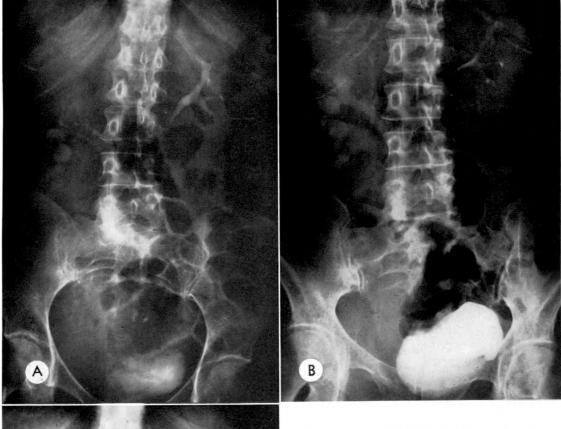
Case iv. (A) Early intravenous pyelogram with 50 cc. of renovist made during episode of right flank pain shows early extravasation of the contrast material in the periureteral tissue around the upper ureter draining the upper collecting system. As noted, the patient has a double collecting system. Notice negative outline of ureter in contrast material. A large right sided pelvic mass indents the right side of the bladder. (B) One-half hour pyelogram shows further extension of extravasation. The ureter to the upper calyces is now outlined with contrast material and separated by the non-opaque wall of the ureter from the extravasated material. The extravasated contrast material also outlines the upper end of the second ureter at this time. (C) Follow-up study a few days later, after subsidence of acute renal colic type symptoms and before roentgen-ray treatment was initiated. The study no longer shows the extravasation. There is persistence of hydronephrosis and hydroureter of the double collecting system, most likely produced by the pelvic mass. This would be a situation of pre-existing disease.
